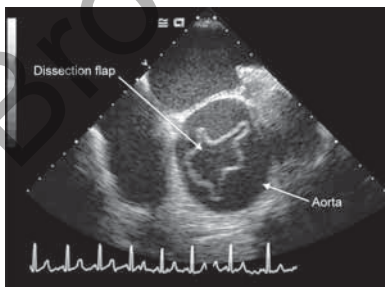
Transesophageal echocardiographic image showing a circumferential intimal flap in the ascending aorta diagnostic of aortic dissection
